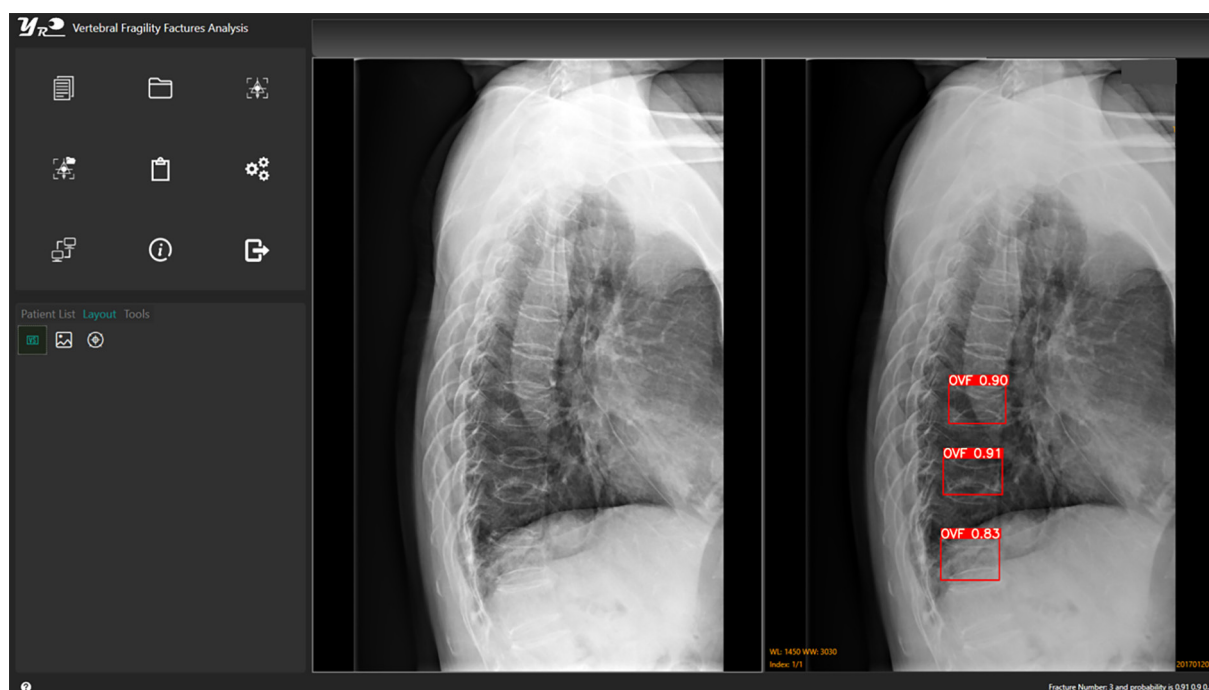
The main operation window of Ofeye 1.0. The image on the left is an original lateral chest radiograph. With the image on the right, three CVFs were labelled on this lateral chest radiograph, with a probability of 0.90, 0.91, and 0.83, respectively. Reference reading confirms these three OVFs. One further minimal grade OVF was missed in this case. OVF, osteoporotic vertebral fracture; CVF, compressive vertebral fracture.
